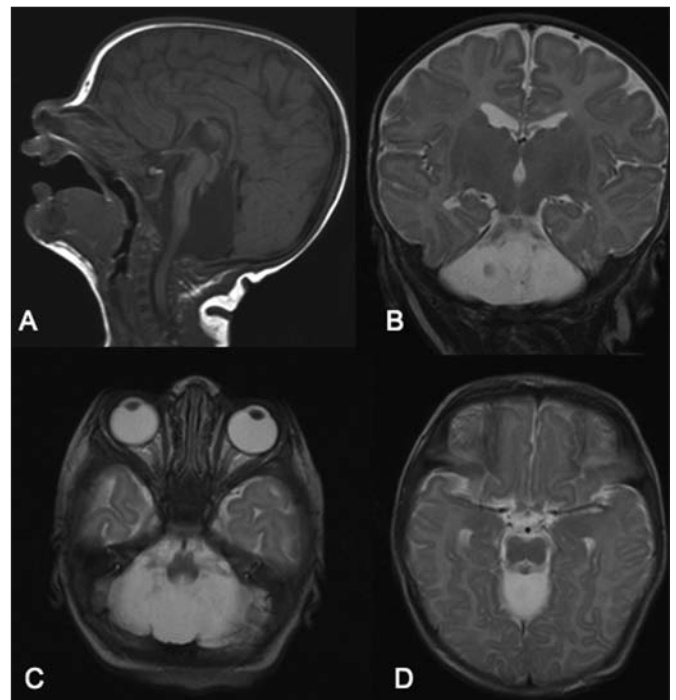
Head MRI performed at eight months-of-age A) Midline sagittal T1 weighted image B) Coronal T2 weighted image, C) Axial T2 weighted image at the level of the medulla, D) Axial T2 weighted image at the level of the midbrain, revealing complete cerebellar agenesis with a normal structural brain and brainstem. Myelination level was appropriate for age.
